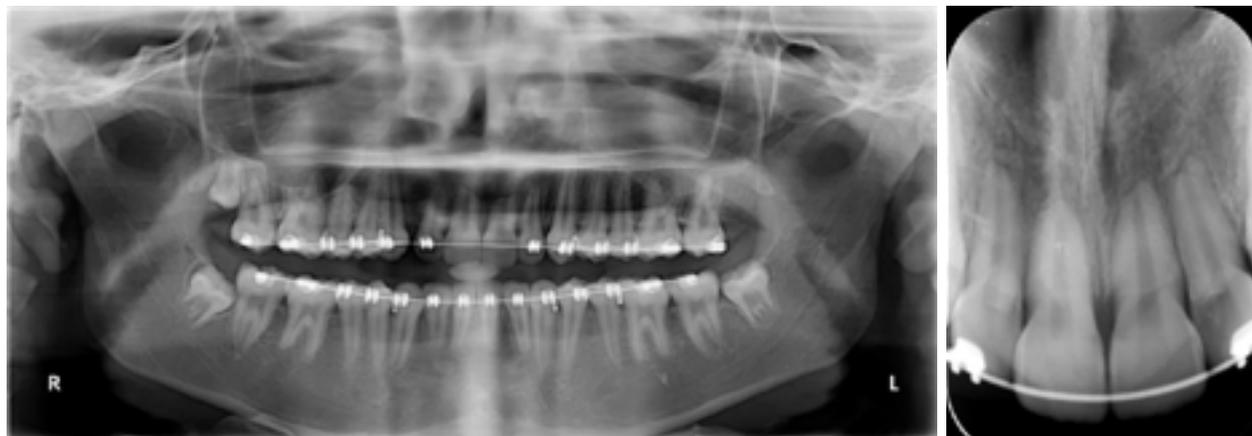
13-month progress PAN and periapical.
